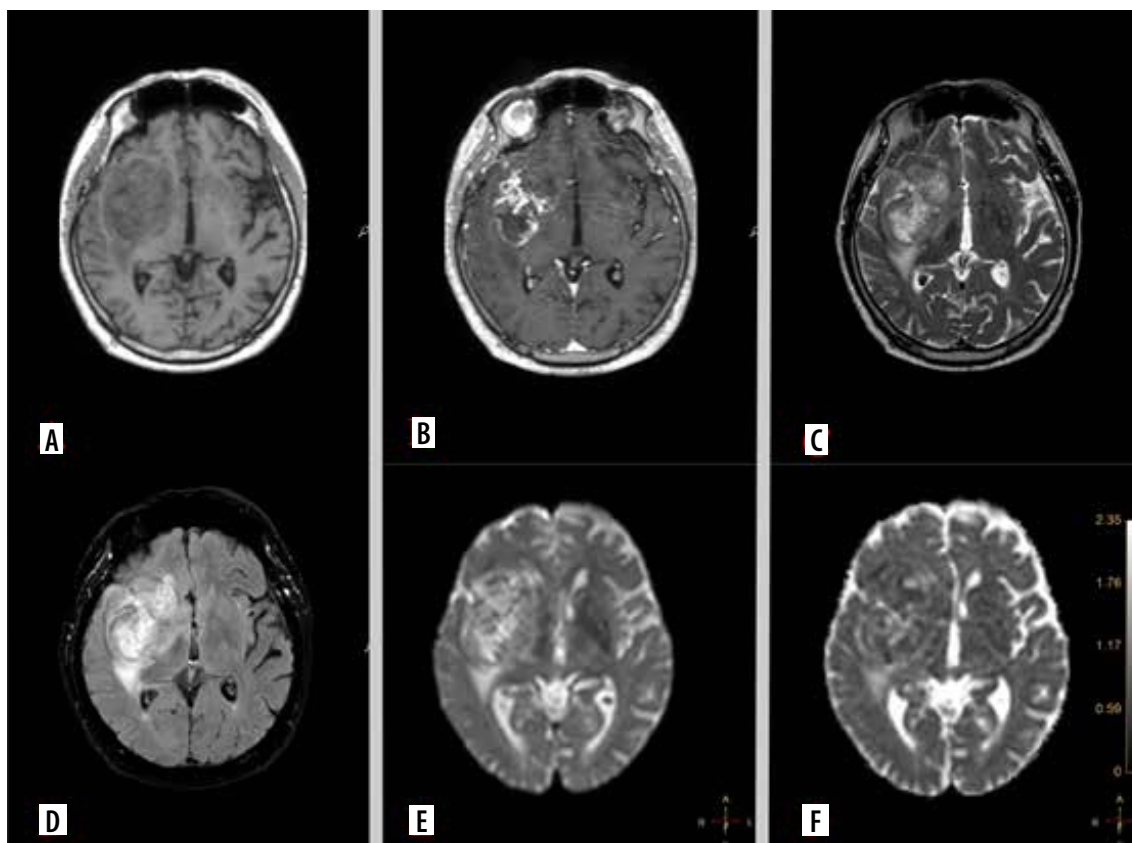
Representative magnetic resonance images of examined patient. A 52-year-old man with glioblastoma G4. Molecular characteristics: *IDH1*-wild-type, present *TERT* promoter pathogenic variant, *CDKN2A* non-deleted, *EGFR* non-amplification, *MGMT* promoter unmethylated. A) Pre-contrast T1. B) Contrast enhanced tumour on T1 post gadolinium. C) T2-weighted scan. D) Fluid-attenuated inversion recovery (FLAIR). E) Diffusion-weighted imaging (DWI).. F) ADC map
